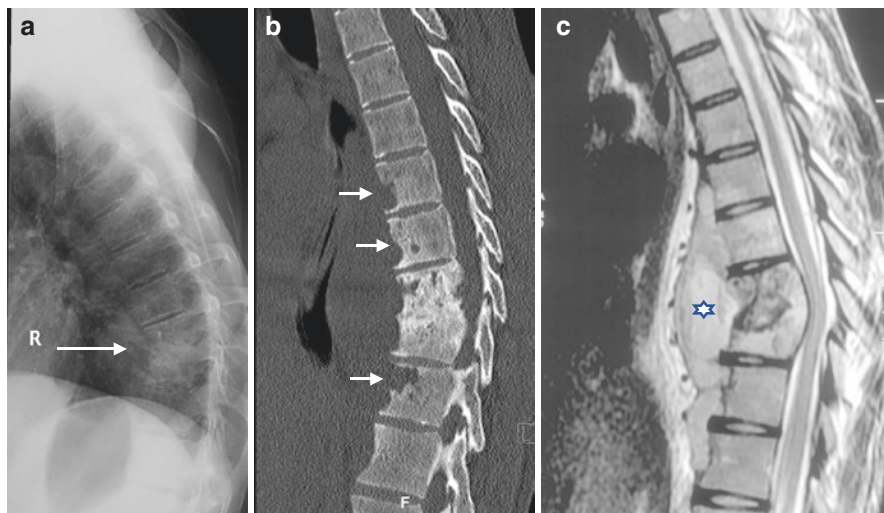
X-ray lateral view DL spine (a) showing loss of D9/10 disc space with adjacent vertebral destruction with focal kyphosis (arrow), NCCT spine sagittal view (b) additionally shows destruction along the anterior aspect of D7, D8 and D11 (short arrow) with relative preservation of the disc spaces at these levels giving the ‘saw tooth appearance’ along with large prevertebral soft tissue. T2 weighted MRI sagittal view (c) reveals the large subperiosteal collection deep to Anterior Longitudinal Ligament (ALL) (asterix) with destruction of adjacent anterior vertebral cortices besides the paradiscal destruction at D9/10 level
